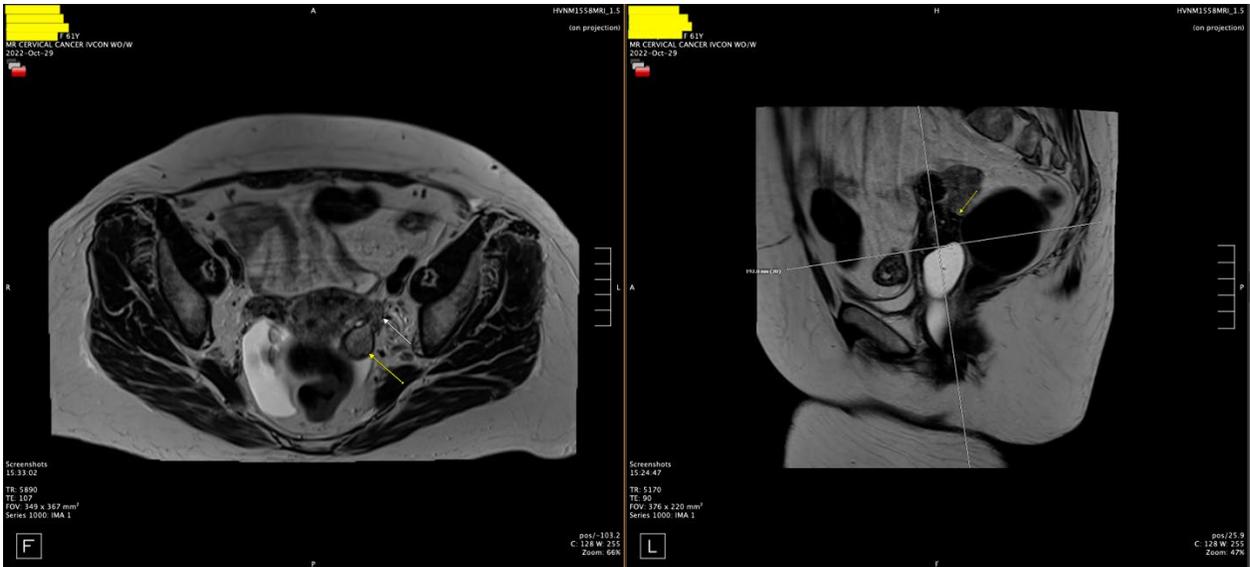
Pelvic MRI with fibrotic scarring from left cervix to the ventral aspect of rectal vault, thickening of the left round ligament, and tenting of the left ovary by a spiculated left pelvic lesion involving the left ureter
